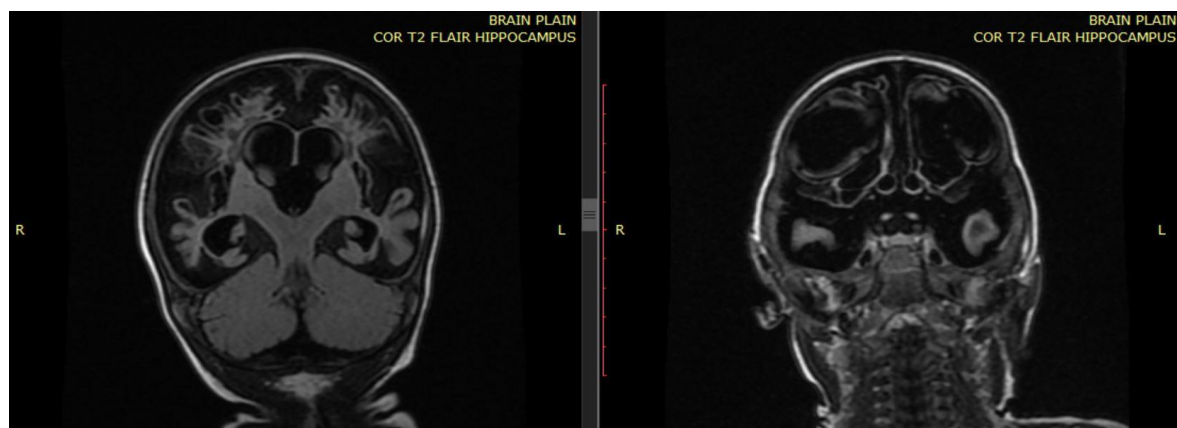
CORONAL FLAIR images of the same patient demonstrating diffuse well-defined areas of CSF intensity with adjacent FLAIR hyperintense rim involving both grey and white matter of bilateral cerebral hemispheres suggestive of cystic encephalomalacia. It is seen causing significant thinning of the cortex. However, both cerebellar hemispheres appear normal.
